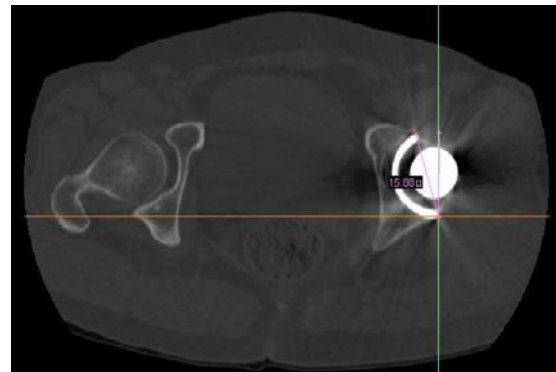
Postoperative CT scan for anteversion angle of acetabular prosthesis
